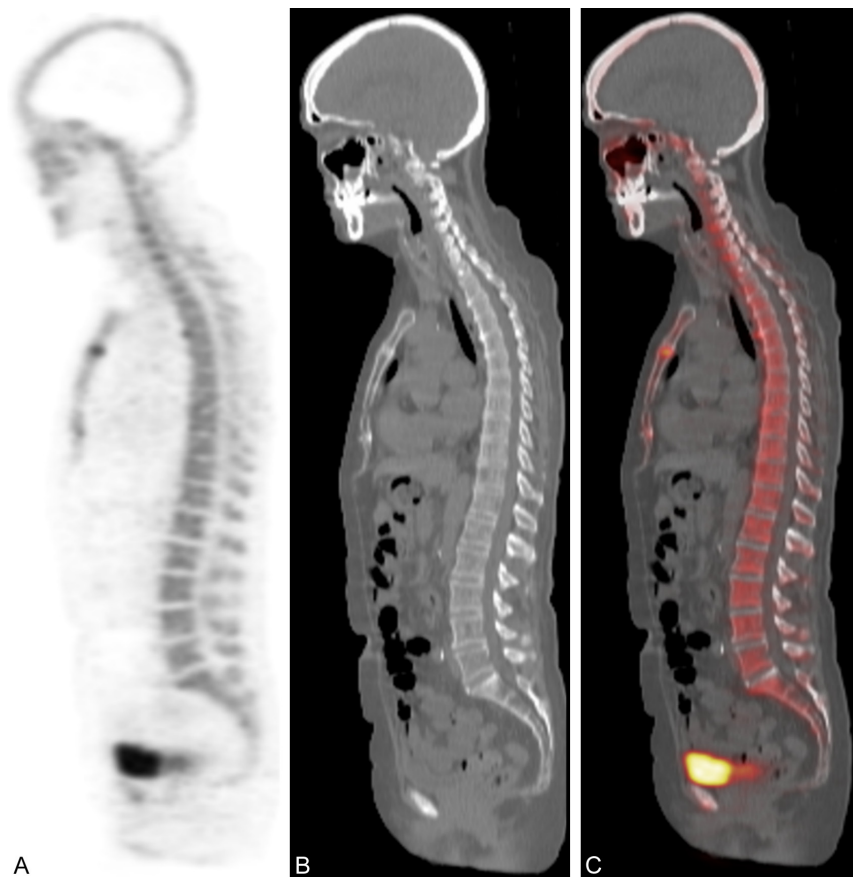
Sagittal views of ^{18}F -NaF PET (A), CT (B), and combined ^{18}F -NaF PET/CT (C) for Case 2.
